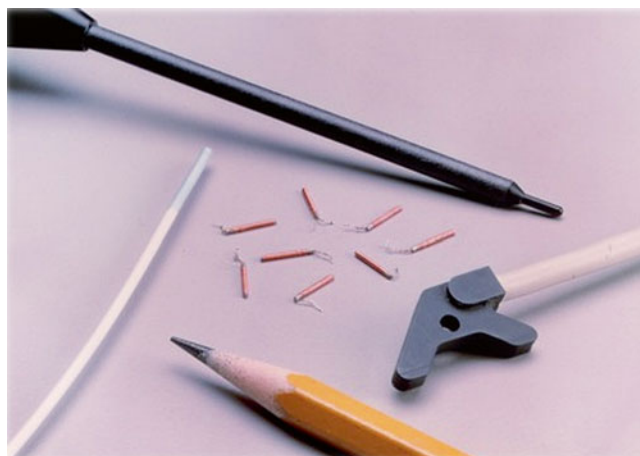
Sensor coils which can be incorporated into ultrasound probes or surgical instruments. These probes function similarly to the optical reflectors in OTSs (Image courtesy of Northern Digital Inc.)
